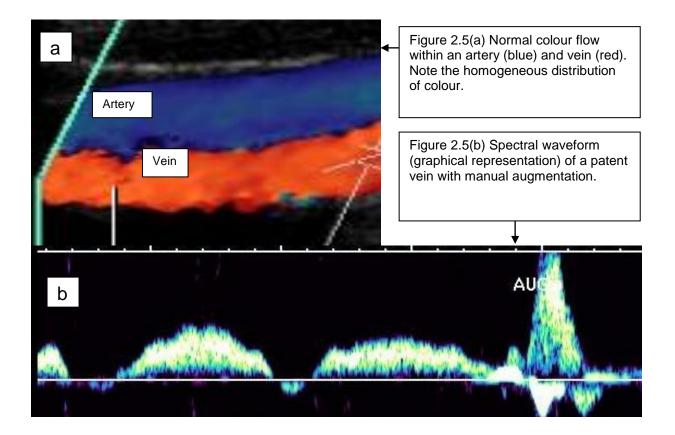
Colour Doppler longitudinal image showing normal colour flow in both the artery and the vein. Figure 2.5b Spectral waveform of a normal vein with augmentation.
